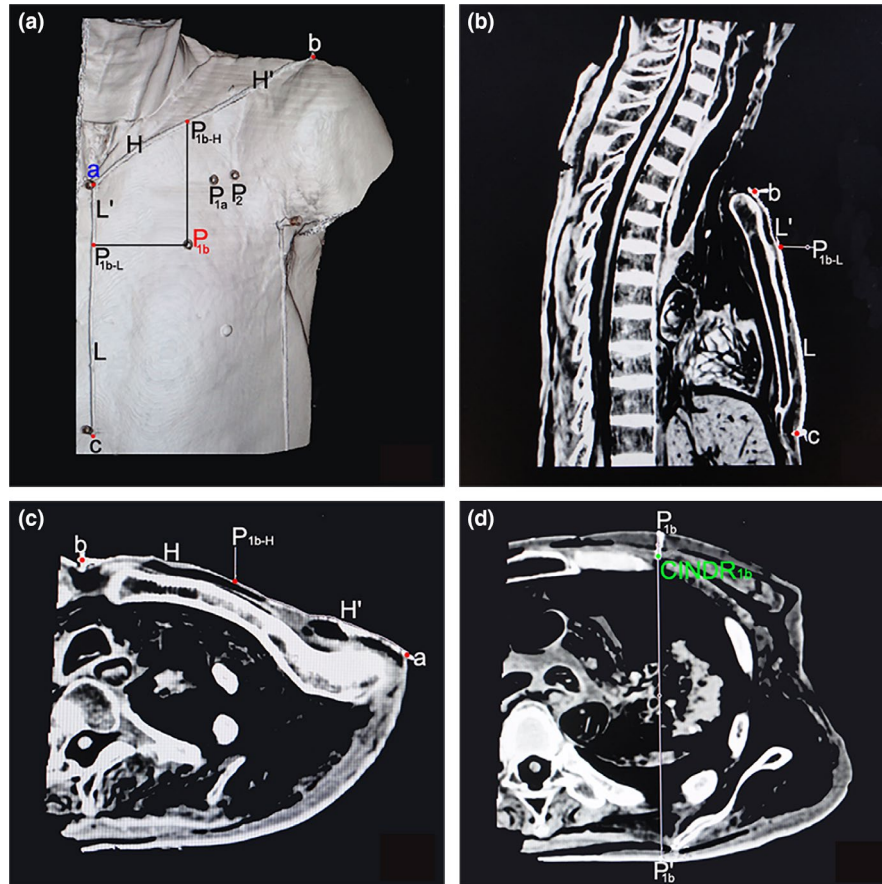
Computed tomography localization of CINDR_{1b} in the pectoralis major muscle. (a) The position of CINDR_{1b} on the body surface (P_{1b}) and the designed reference line. (b) The length of the L and L' lines measured on the sagittal section. (c) The length of the H and H' lines measured on the cross-section. (d) The depth of CINDR_{1b}, measured on the cross-section
